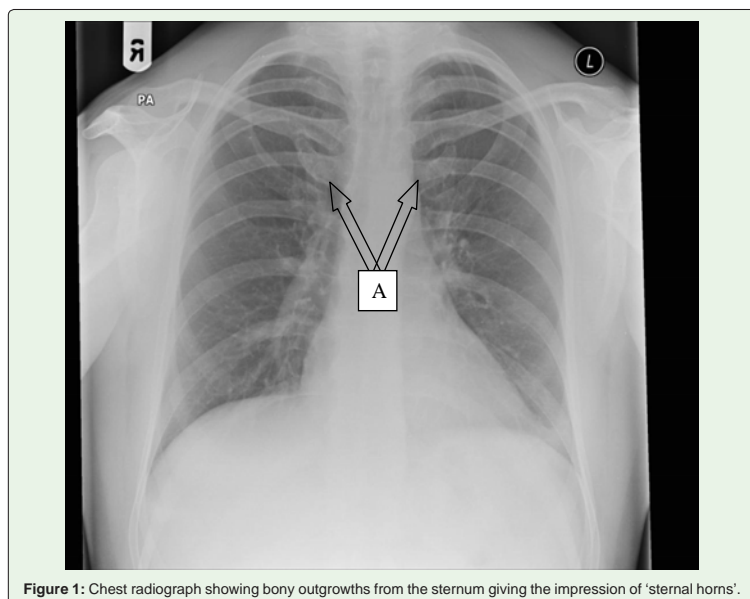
Chest radiograph showing bony outgrowths from the sternum giving the impression of 'sternal horns'.
